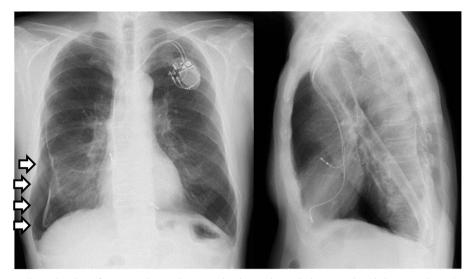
Chest radiograph 4 days after pacemaker implantation The chest radiograph shows a right-sided pneumothorax (open arrows).
